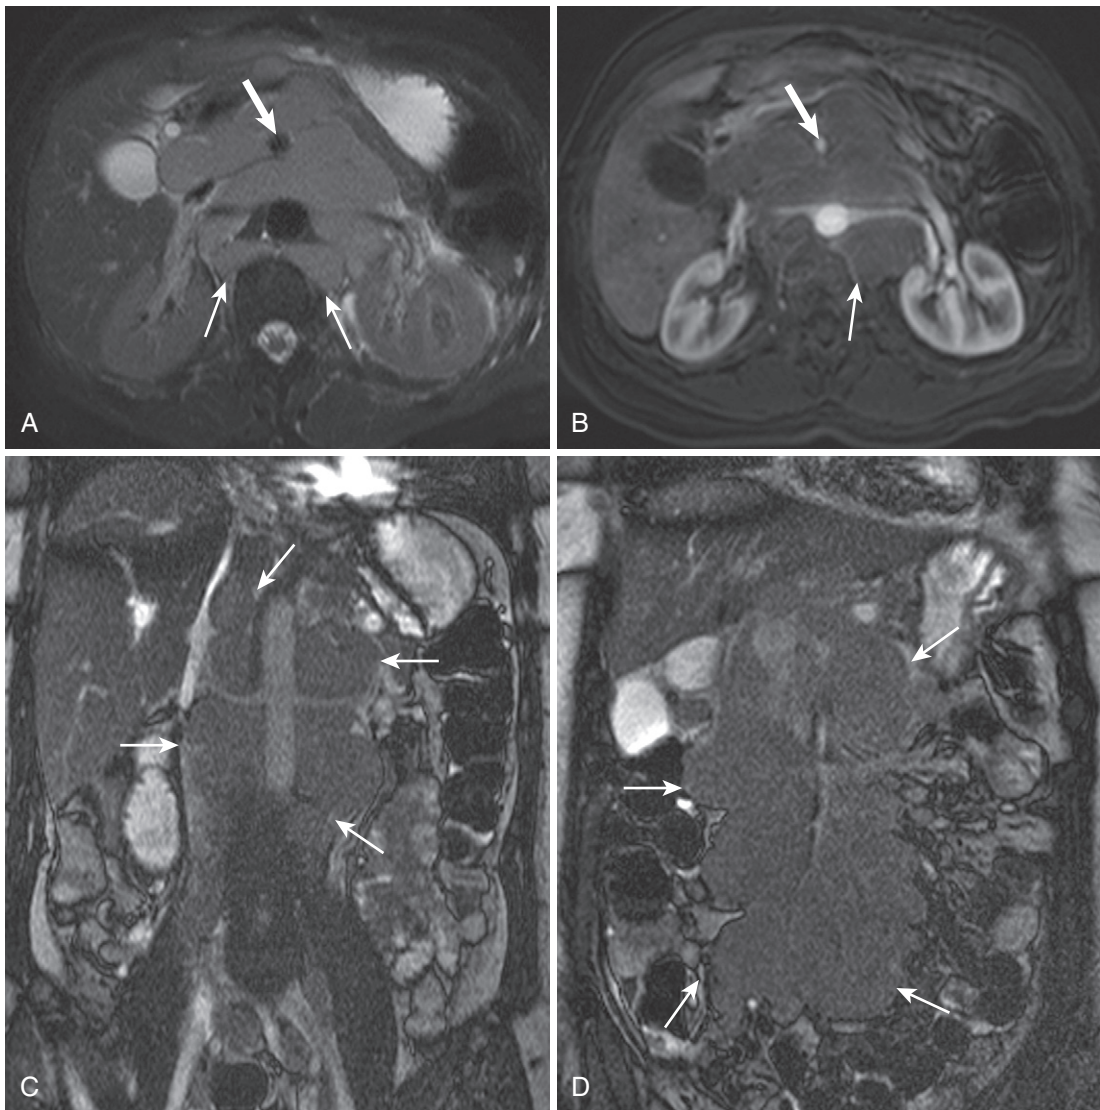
Retroperitoneal lymphoma. The T2-weighted fat-suppressed (A) and postcontrast (B) images depict nearly coalescent lymph nodes throughout the retroperitoneum, including retroaortic extension (*thin arrows*), with monotonous features—homogeneous T2 hyperintensity and modest homogeneous enhancement. Encirclement of the superior mesenteric artery (SMA; *thick arrow*) denotes concurrent mesenteric involvement. C and D, The coronal steady-state images show the extent of craniocaudal involvement (*arrows*).
